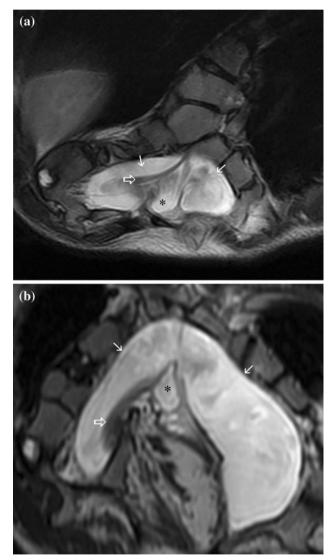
T2-weighted axial (a) and coronal (b) MR images show splitting of the thecal sac into two discrete sacs (*arrows*) where each one of them follows the duplicated spine components. The right-sided thecal sac includes spinal cord (*open arrow*). Note a third cystic structure containing neural elements and surrounded by fat tissue located in the midline (*asterisk*)
